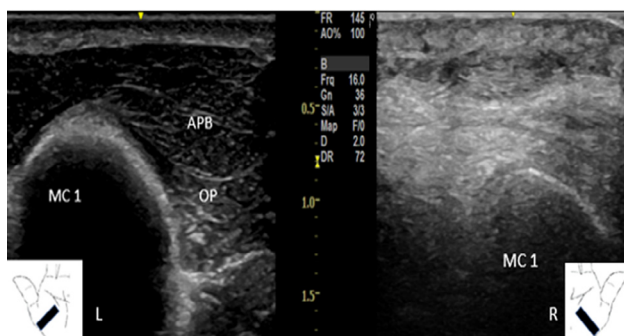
Ultrasound image of thenar muscles (short axis view) in patient 6: Congenital thenar hypoplasia in the right hand and normal thenar muscles in the left hand. Abbreviations: APB: Abductor pollicis brevis, OP: Opponens pollicis, MC1: 1st Metacarpal bone.
